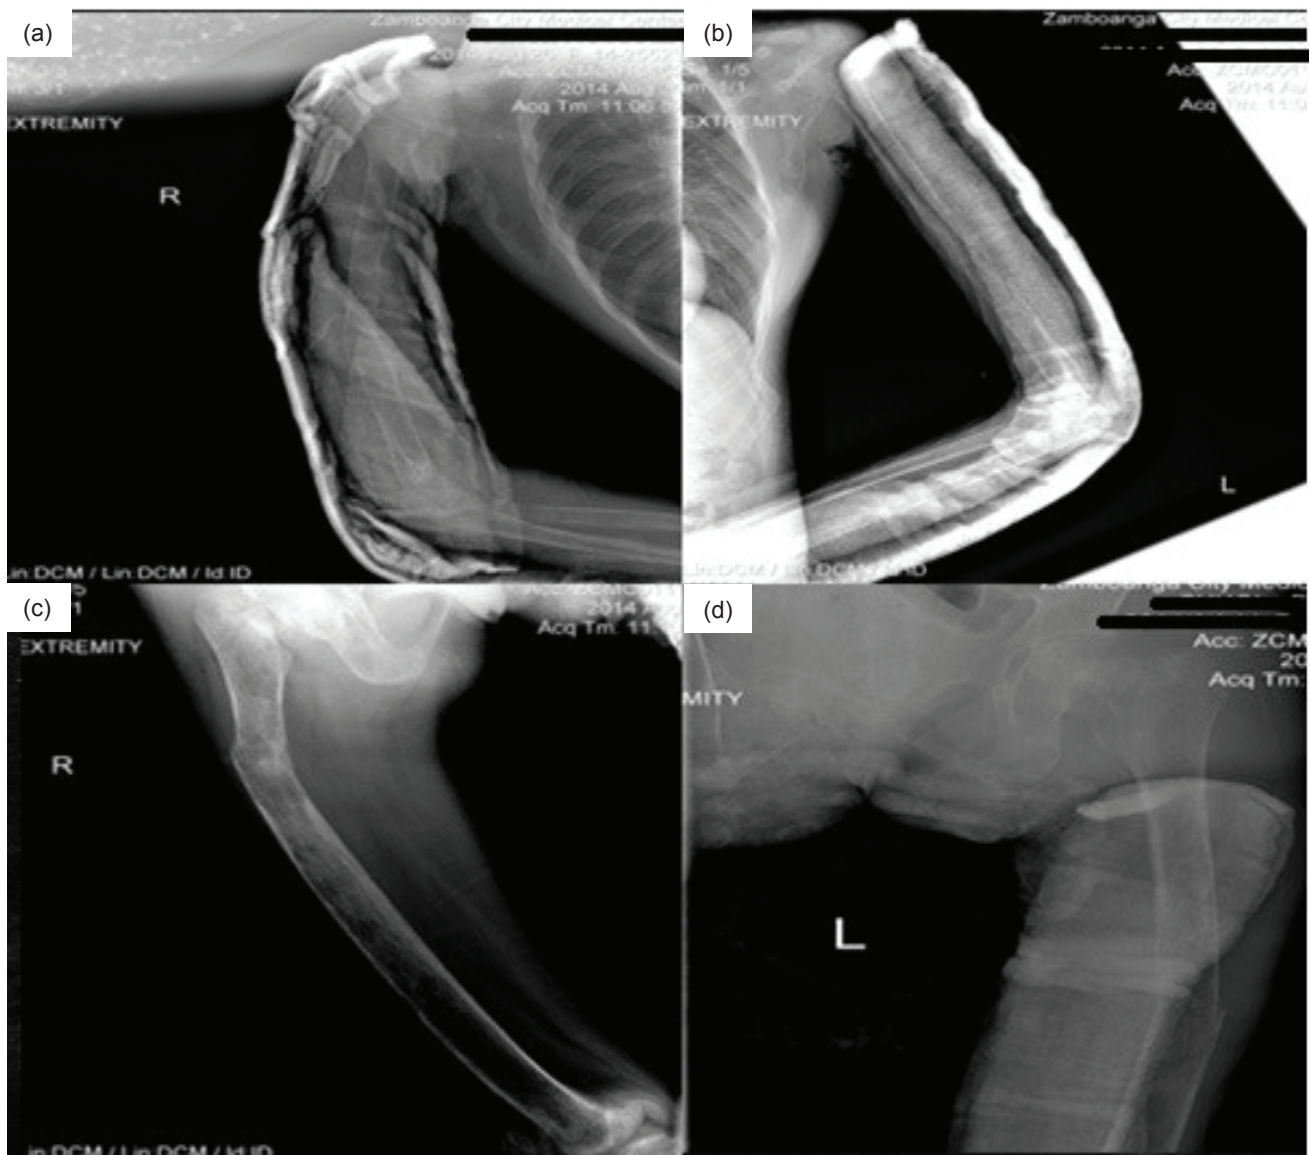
X-rays of the right humerus (a), left humerus (b), right femur (c) and left femur (d) done 3 weeks after surgery. Callus formation was seen at the fractured segments with moderate to severe osteopenia.
